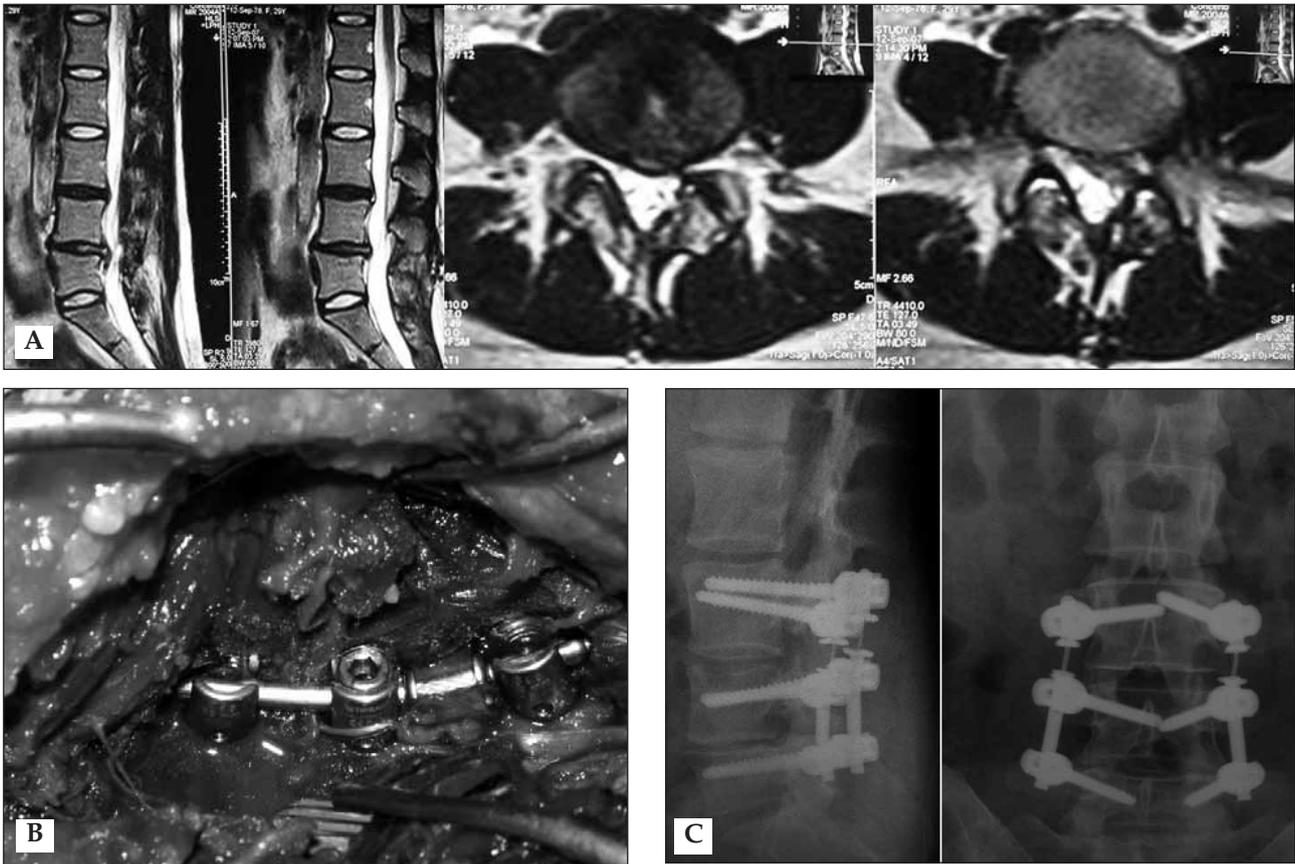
A 30-year-old female patient was operated on two years previously due to a herniated lumbar disc (patient #6). The patient had severe back and left leg pain. A) MRI examination showed a recurrence at the same level and a painful black disc at the adjacent segment (confirmed with discography). B) An agile rod was used with dynamic screws. The mobile part is facing the painful black disc. C) Antero-posterior and lateral radiographic views after the operation.
